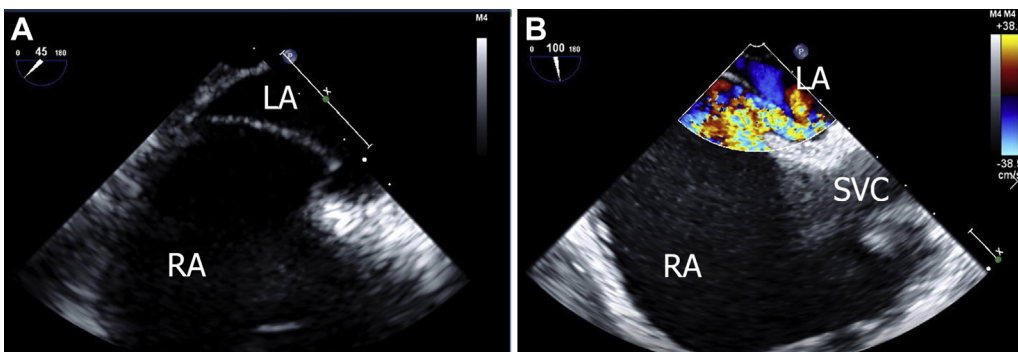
(A) Midesophageal four-chamber view with zoom on interatrial septum to show bowing of from the right atrium (RA) to the left atrium (LA). (B) Midesophageal bicaval view with color flow Doppler showing significant right-to-left shunt through patent foramen ovale. SVC, Superior vena cava.
